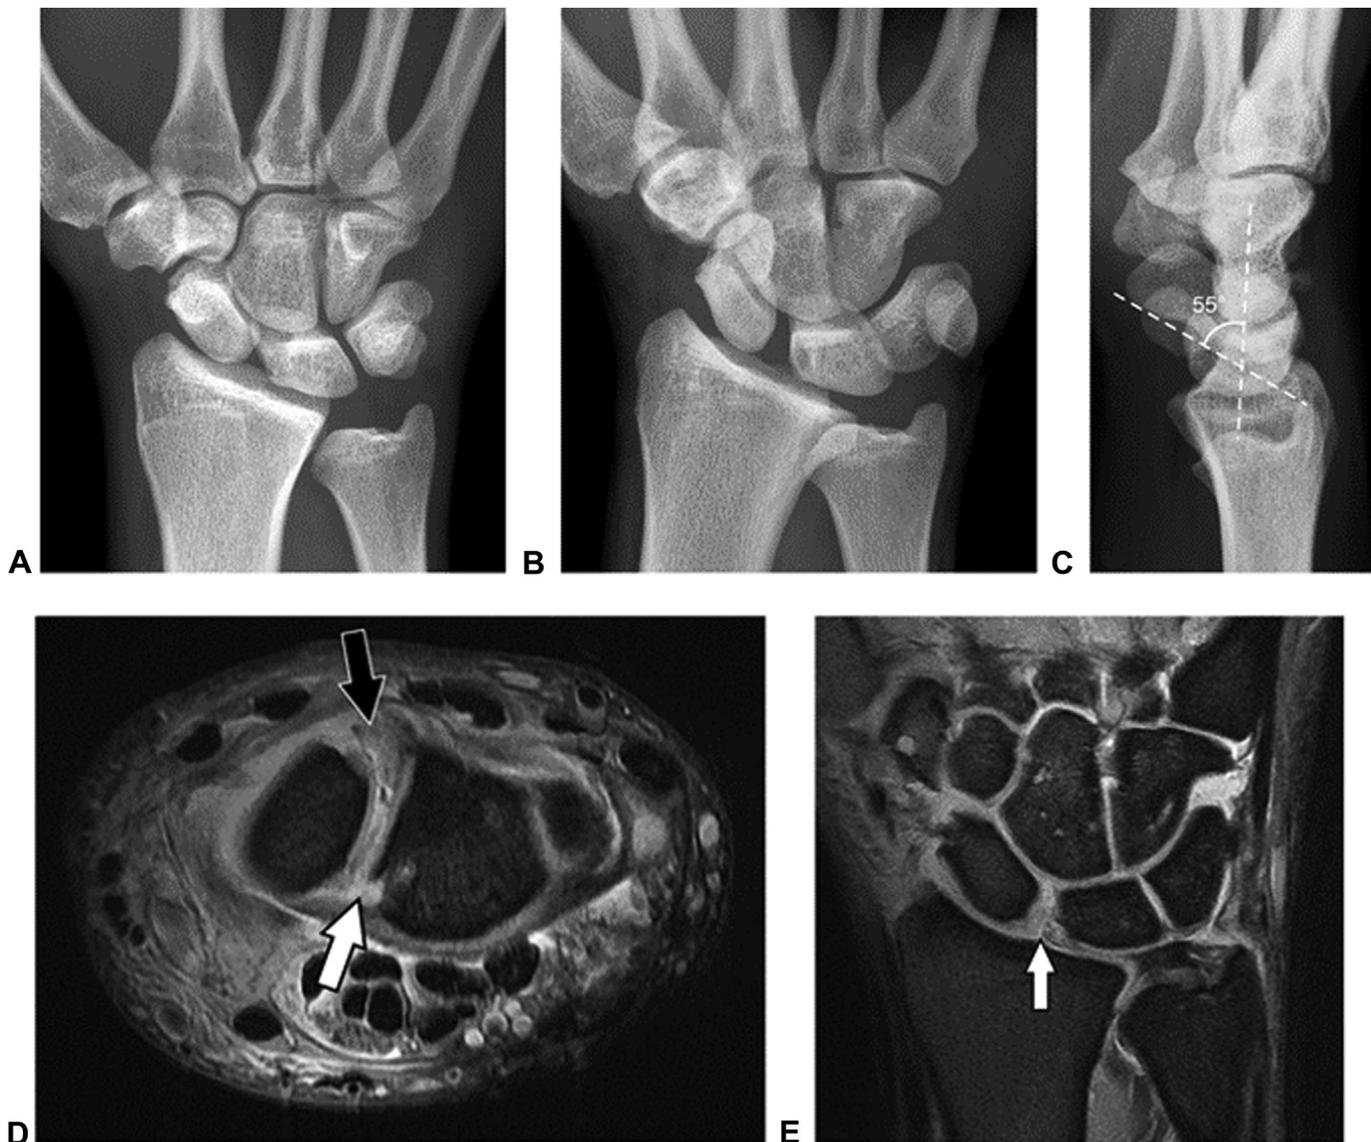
Stage 3 SLIL injury with normal static alignment in a 25-year-old professional American football player who experienced a fall 3 months earlier. A Static posteroanterior radiograph shows a scapholunate interval of 2.7 mm. B Dynamic clenched fist radiograph shows an increase in the scapholunate interval to 4 mm. C Lateral radiograph shows a normal scapholunate angle of 55°. D Axial PDW fat-suppressed MR image shows a torn SLIL dorsal band (black arrow) from the scaphoid attachment and a torn SLIL volar band (white arrow), which were confirmed at surgery. E Coronal PDW fat-suppressed MR image shows a torn SLIL interosseous band (arrow). Reparability of the SLIL dorsal band can be suggested with imaging if the tear appears noncomplex and nonelongated but is ultimately determined at surgery. (Adapted with permission from Palisch et al¹⁰¹).
